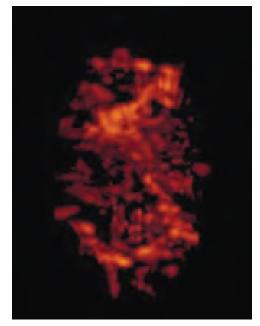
Power Doppler mapping reveals spokewheel pattern vascularity in the adenomyoma
